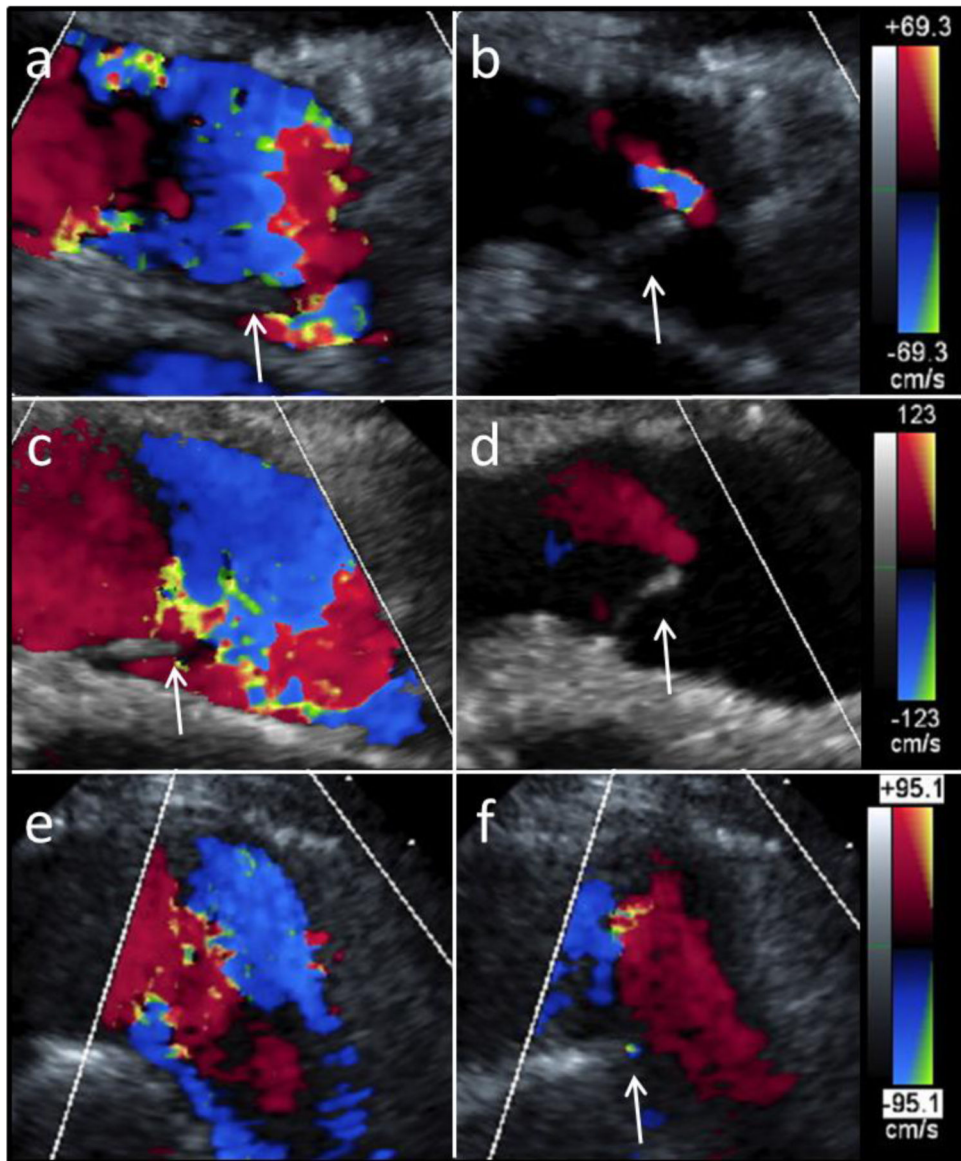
Long axis ultrasound images of the valve (a,b) 1 week, (c,d) 8 weeks, and (e,f) 20 weeks after implantation. Representative images during (a, c, e) systole and (b, d, f) diastole show valve opening and closing, respectively. For all images, the right ventricle is on the left-hand side and the arrows point to the visible leaflets. Doppler scale bars for each time point are shown on the right.
